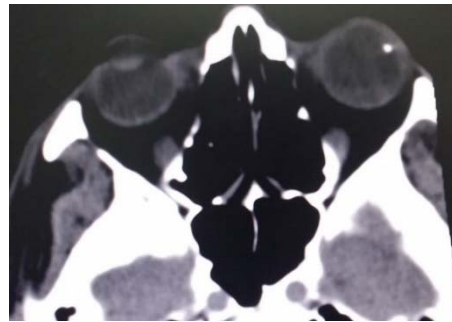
Repeated CT orbit axial cut post-operatively revealed left eye globe retained radio-opaque IOFB similar to pre-operative imaging.
